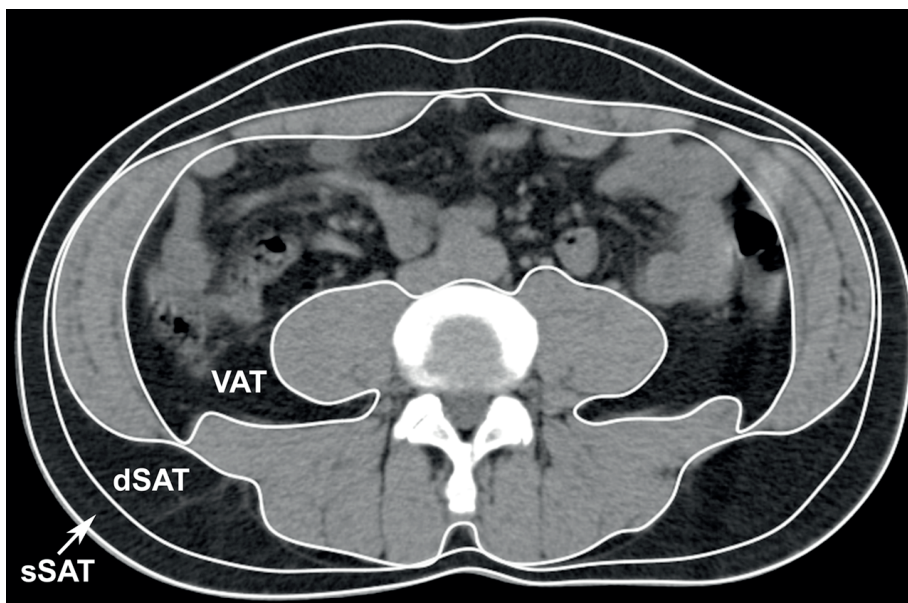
Axial CT scan at level $L_{3/4}$ showing VAT (visceral adipose tissue), dSAT (deep subcutaneous adipose tissue) and sSAT (superficial subcutaneous adipose tissue).
